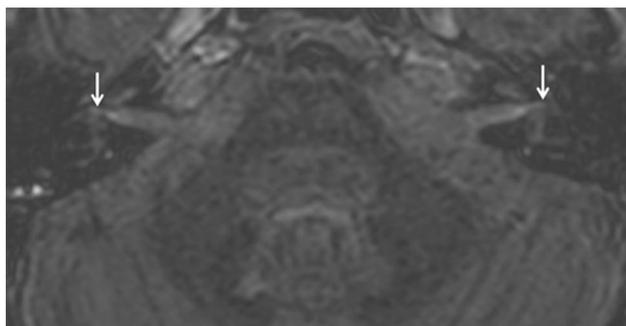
Delayed contrast-enhanced FLAIR sequence, axial plane, acquired 1 h after intravenous gadolinium sequence in a normal patient showing no pathological enhancement of the superior vestibular nerves on the right and left side (50 units, arrows)
